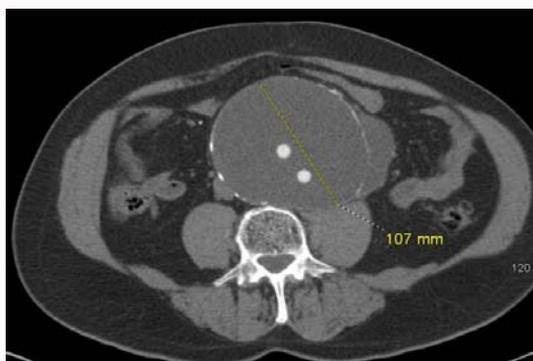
Computed tomography (CT) scan shows large aneurysm sac without evidence of an endoleak or contrast extravasation from 3 years prior.
